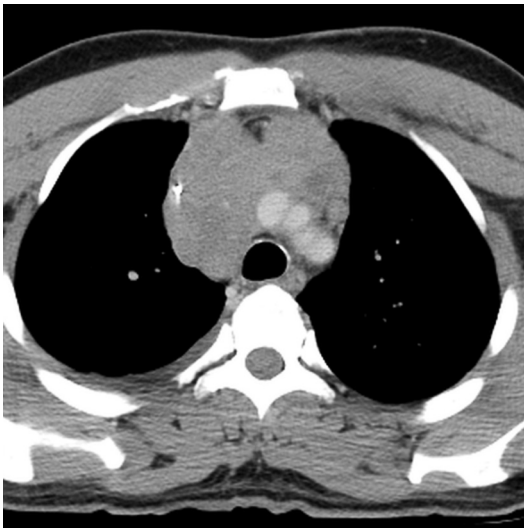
Seminoma. Contrast-enhanced axial CT shows a locally invasive, relatively homogeneous prevascular mediastinal soft tissue mass that extends into the visceral mediastinum and obliterates the brachiocephalic veins and upper superior vena cava.
